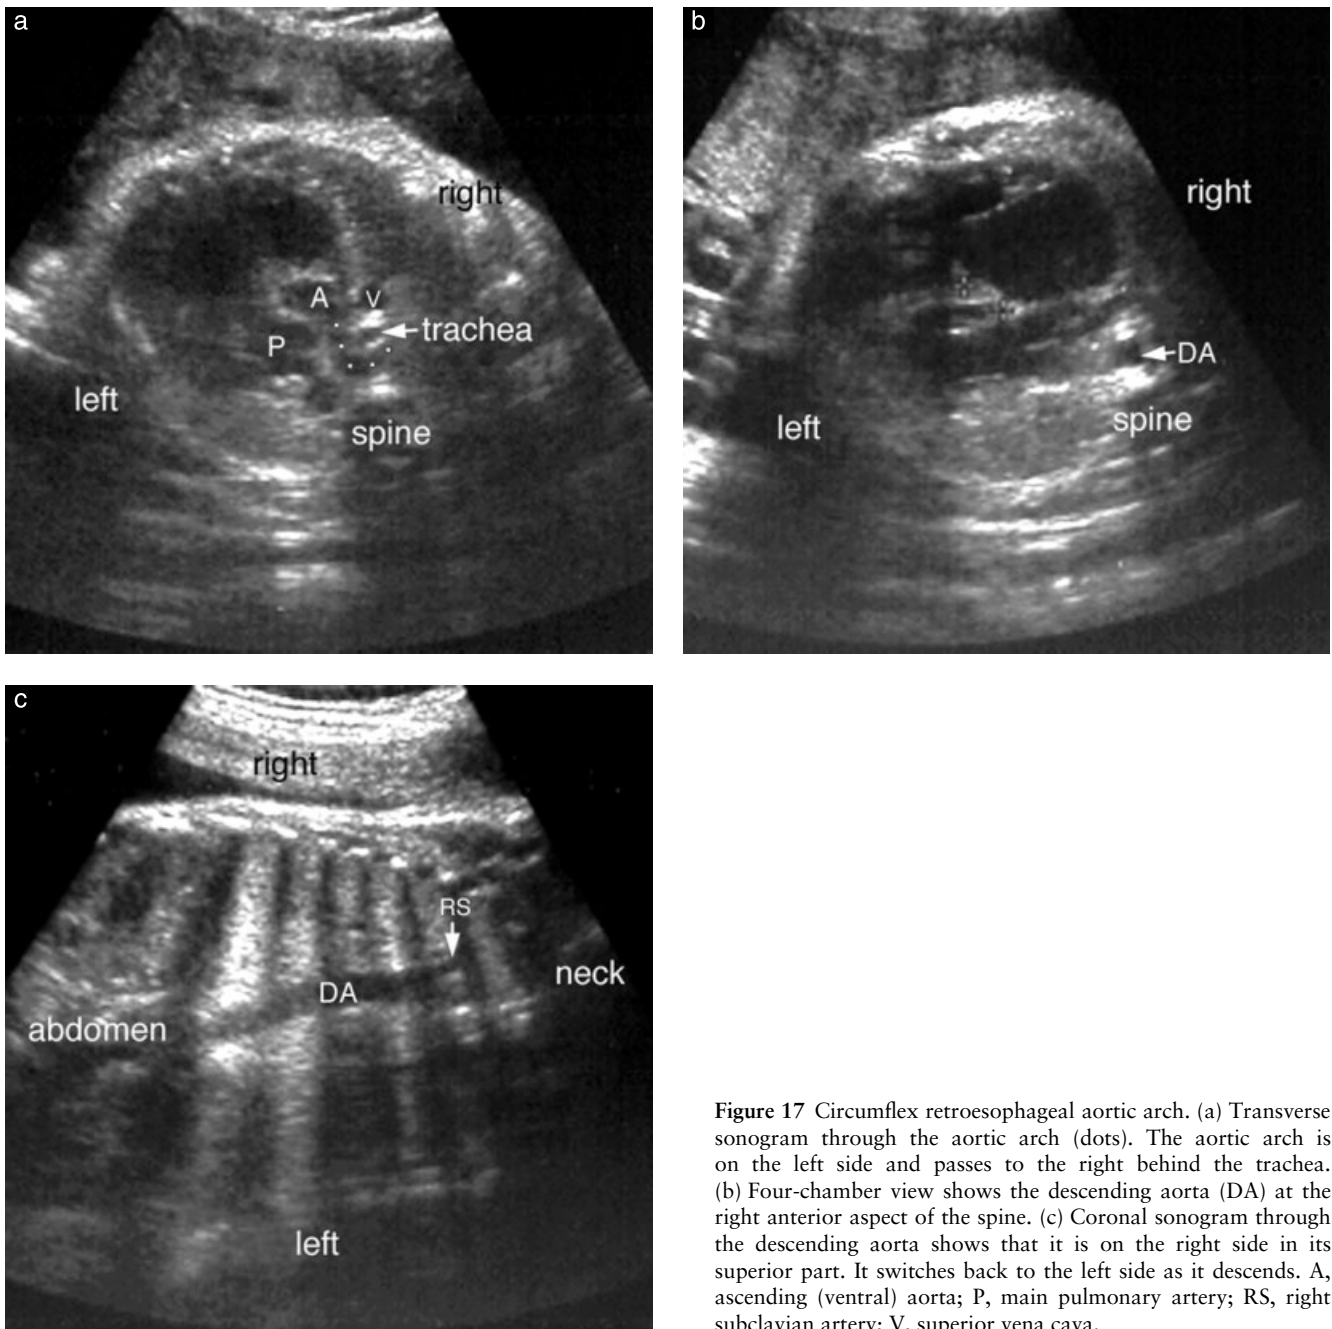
Circumflex retroesophageal aortic arch. (a) Transverse sonogram through the aortic arch (dots). The aortic arch is on the left side and passes to the right behind the trachea. (b) Four-chamber view shows the descending aorta (DA) at the right anterior aspect of the spine. (c) Coronal sonogram through the descending aorta shows that it is on the right side in its superior part. It switches back to the left side as it descends. A, ascending (ventral) aorta; P, main pulmonary artery; RS, right subclavian artery; V, superior vena cava.
